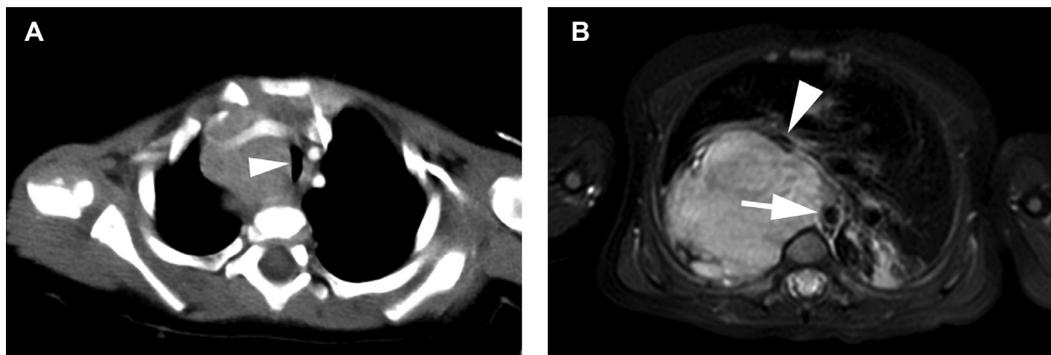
Airway compression, consistent with the presence of an IDRF (L2). (A) Contrast-enhanced CT in a 1-year-old girl with a superior mediastinal mass showing *compression* and displacement of the trachea (arrow head). (B) Axial T2-weighted MR image in a 1-year-old boy demonstrates a right mediastinal mass *compressing* the right main bronchus (arrow head) and making *contact* with the descending aorta (arrow) (not a second IDRF).
